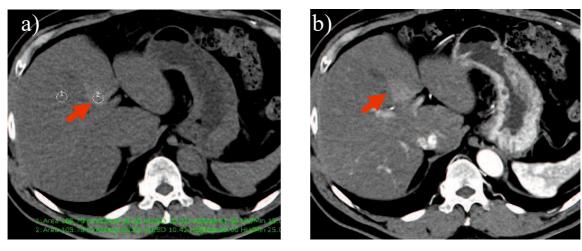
びまん性脂肪肝、FSA あり (a)単純 CT (b)動脈相 CT
